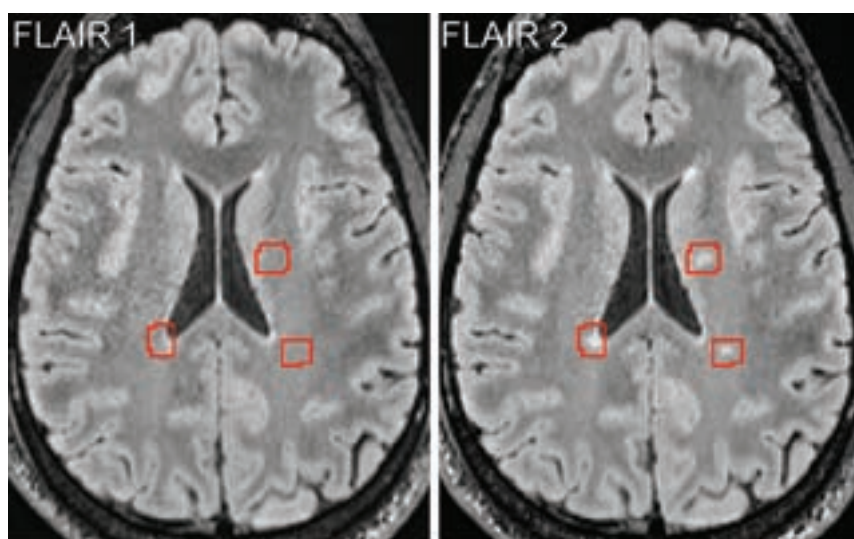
Longitudinal axial FLAIR images acquired from a patient with MS approximately 10.5 months apart, showing an example of 3 new lesions detected by human readers who were assisted visually by the SDC algorithm, which delineates brain areas containing potential new lesions for human confirmation (red boxes) (referred to as Reader + SDC method).
